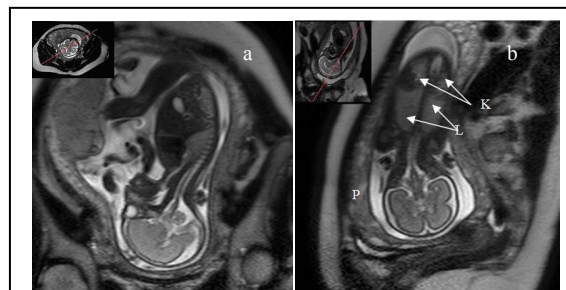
Magnetic Resonance Imaging (HASTE sequences): (a) Sagittal plane through fetus and (b) Coronal plane through fetus. K=kidney and L=lungs
